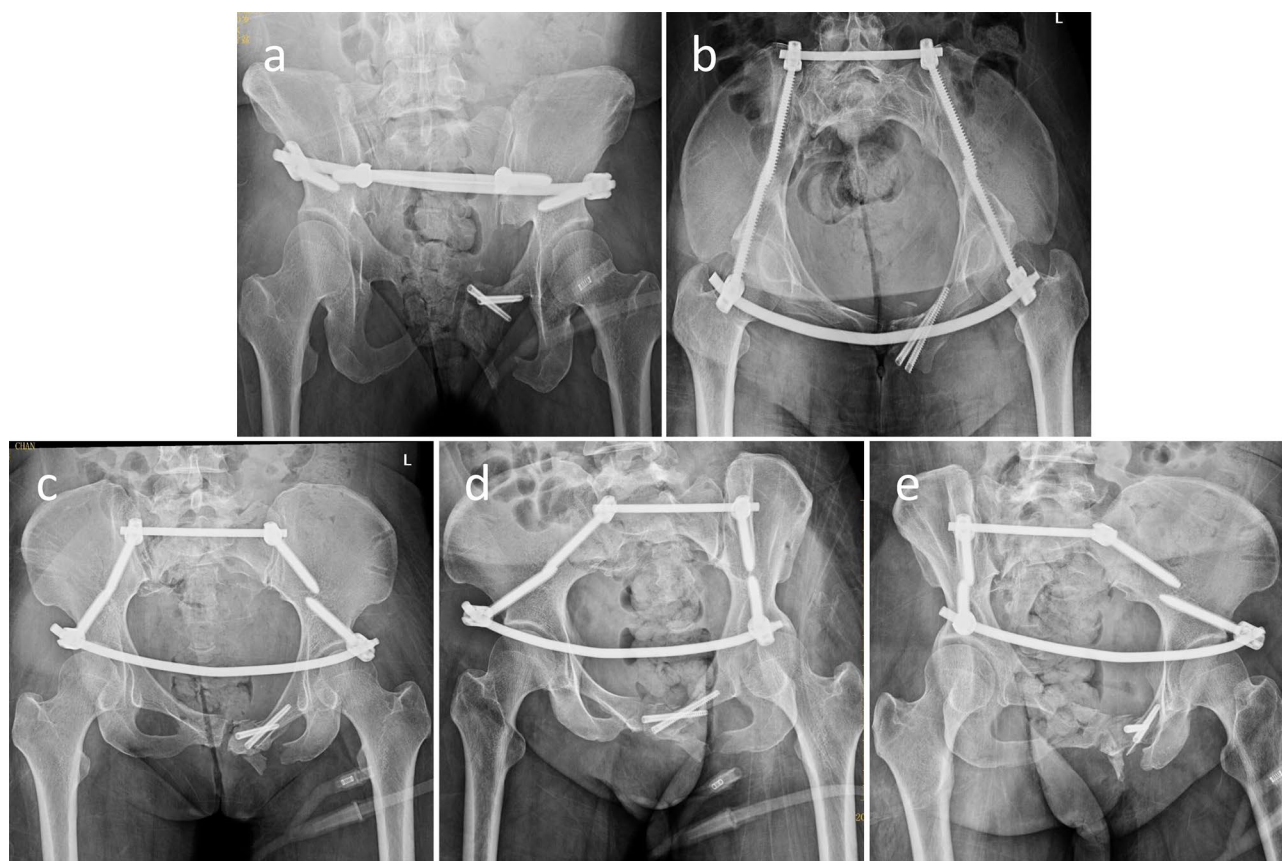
Case 1: X-ray images at 2 days postoperatively showing that the anterior and posterior rings were adequately reset. Percutaneous impaction of two cannulated screws in left suprapubic ramus. The internal fixation was reliable (a-e)
